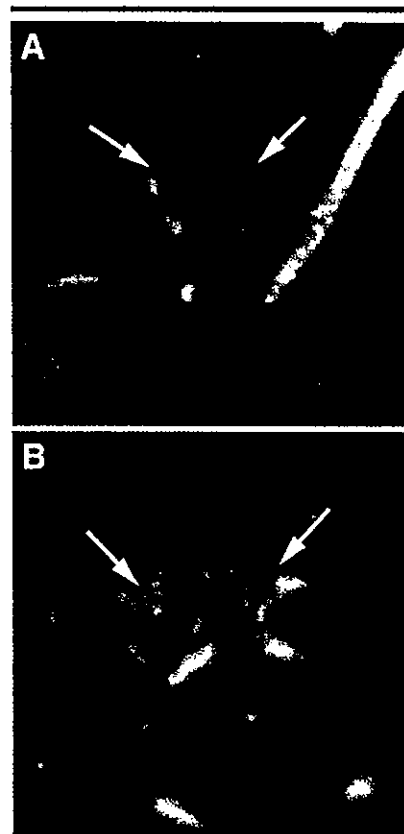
Transverse thin-section CT images. A, Image shows a malignant pure GGO lesion (adenocarcinoma) with a round shape (arrows). B, Image shows a benign pure GGO lesion (resolved within 3 months) with a polygonal-complex shape (arrows) that is confined to a secondary lobule.
